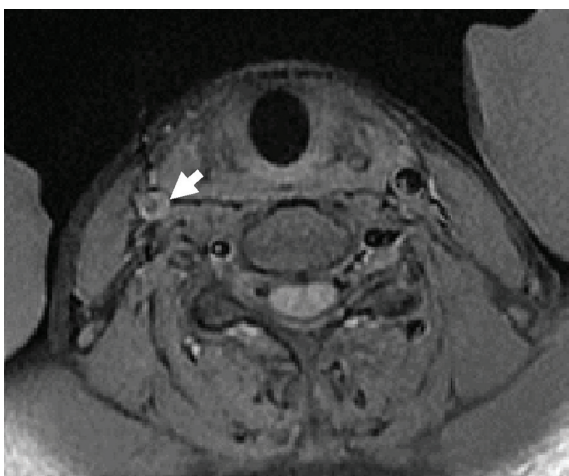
Magnetic resonance imaging T1-weighted image with fat suppression technique showing crescentic hypersignal intensity due to intramural hematoma (arrow) at cervical segment (C1) in right internal carotid arterial dissection.
